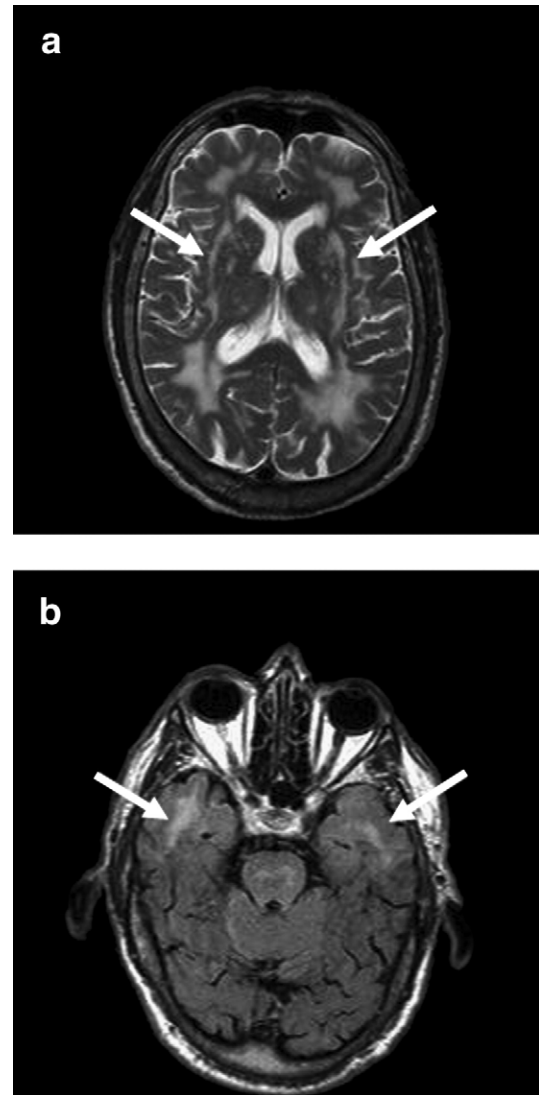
Cerebral MRI. Extension of leukoencephalopathy to the external capsule bilaterally (arrows) on an axial T2-weighted image (a), and to the anterior temporal poles (arrows) on an axial FLAIR image (b).
